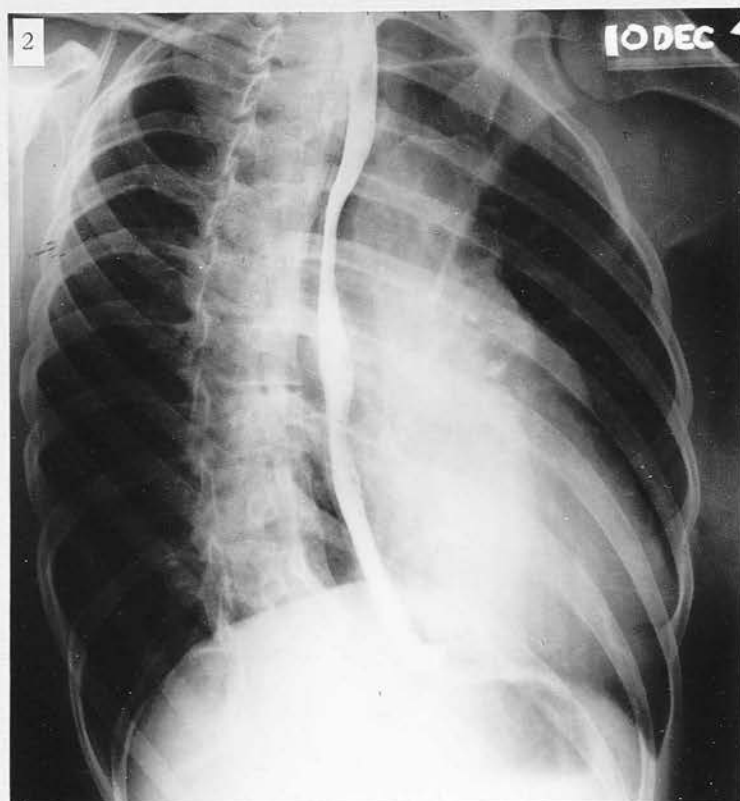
Radiograph of Case 59. Large Patent Ductus in early adult life.
